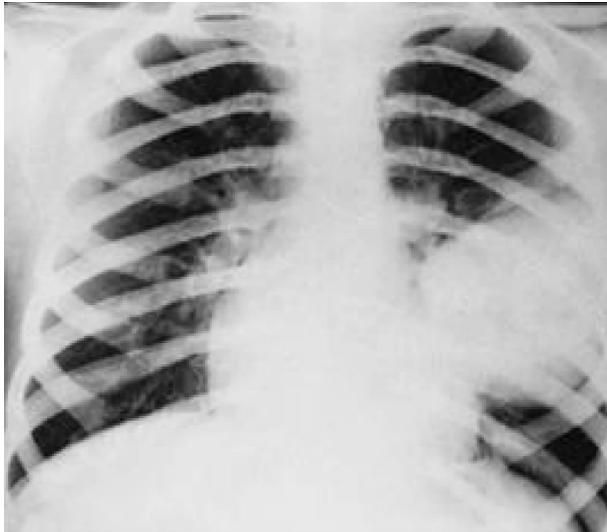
Chest X-ray image of complicated hydatid cyst with pleural complication.
